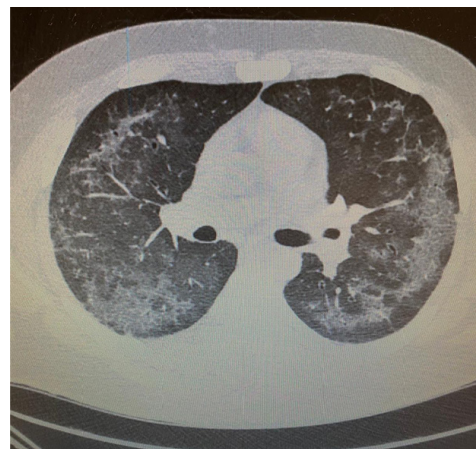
Initial non-contrast chest CT on admission demonstrates ground-glass opacities involving bilateral lung fields. area of sub-pleural sparing (red arrows)
